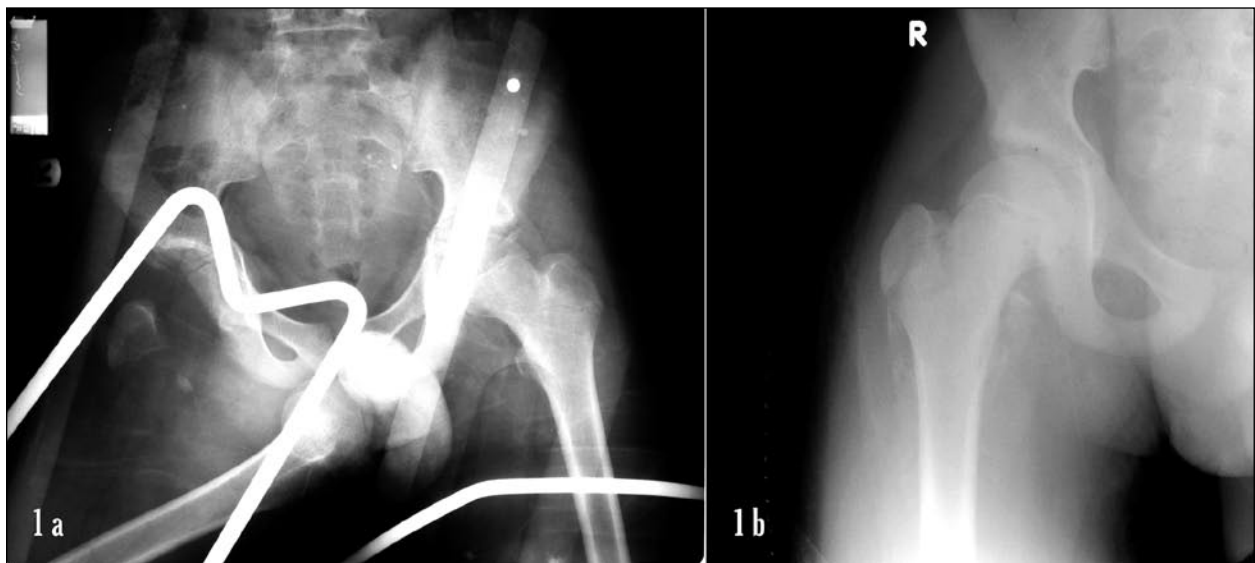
Anteroposterior radiograph of the pelvis, presenting perineal right hip dislocation with ipsilateral avulsion fracture of the greater and lesser trochanter of the right femur before (a) and after (b) surgical procedure
